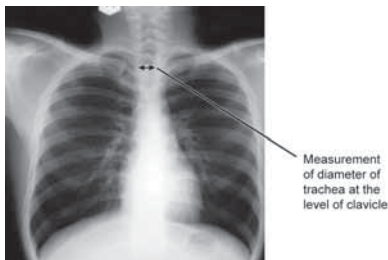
X-ray-guided measurement of tracheal width
